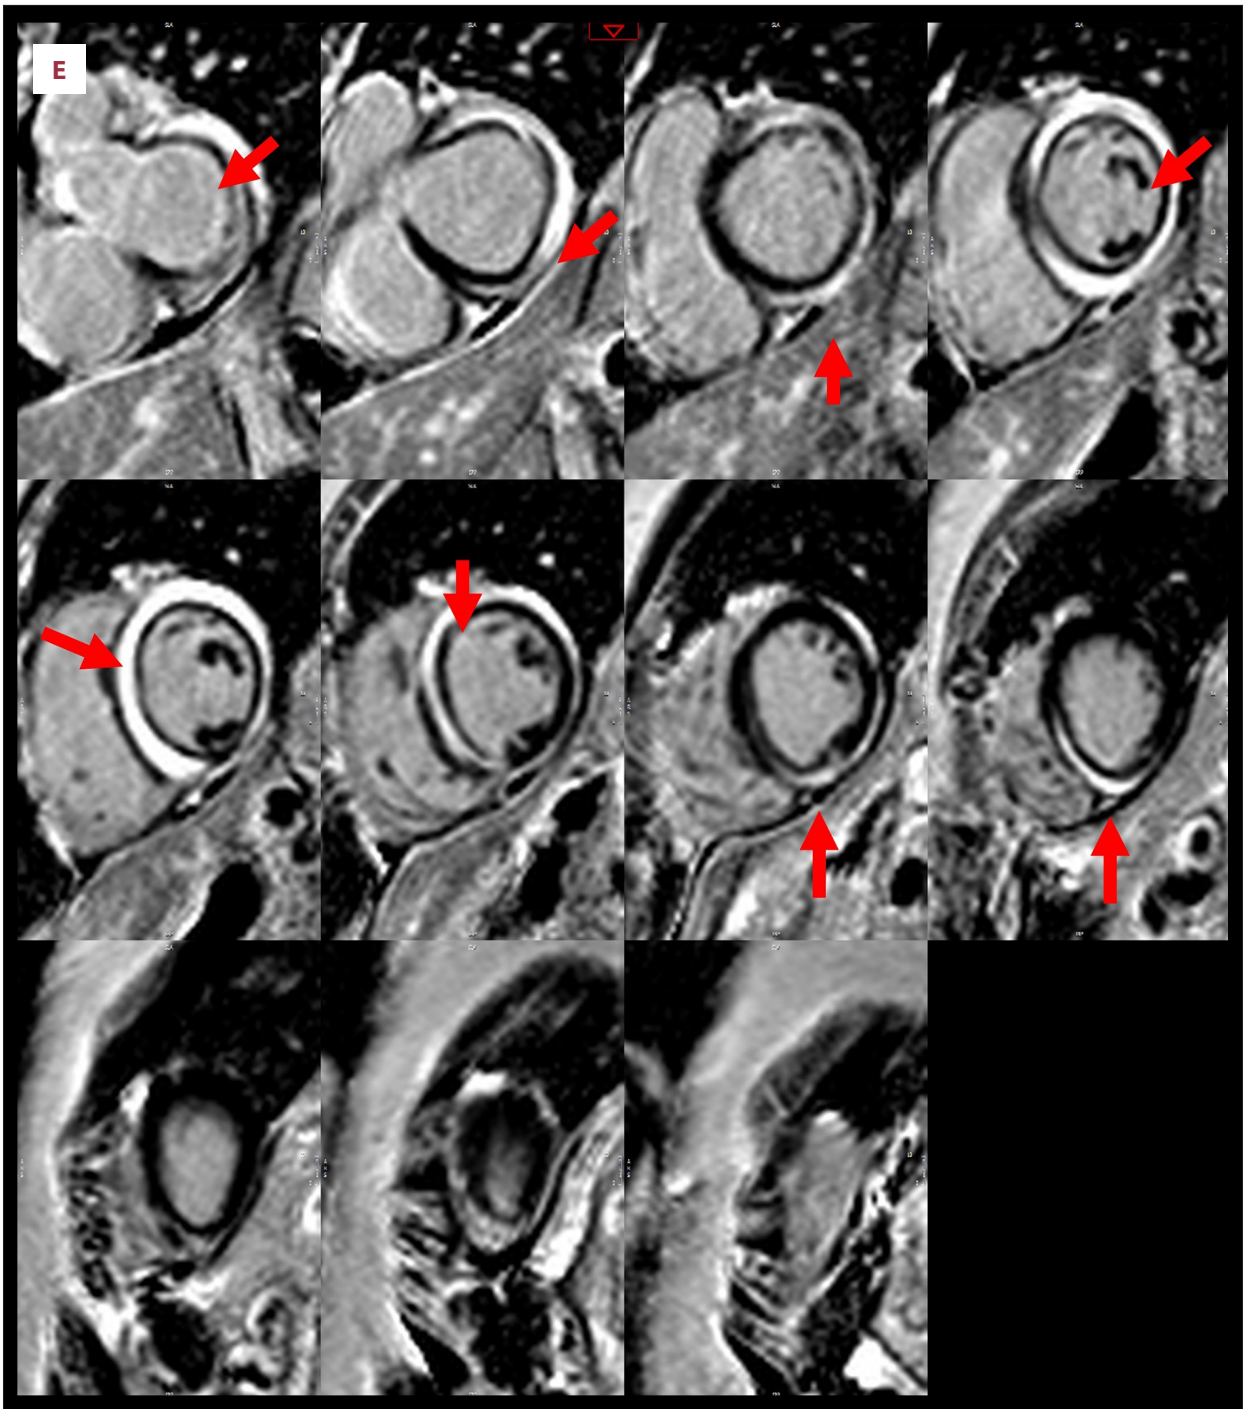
Cardiac MRI images demonstrating evidence of myocarditis. (A) STIR acquisition of mid-ventricular short axis: increased T2 signal intensity (SI) in the myocardium (SI myocardium: 275, SI skeletal muscle: 100). (B) MOLLI T1 map of mid-ventricular short axis: diffusely and focally (green arrows) increased T1 values (T1 mid-septal: mean 1170 msec, maximum 1364 msec). (C) T2-prepped SSFP T2 map of mid-ventricular short axis: diffusely- and focally-increased (blue arrows) T2 values (T2 mid-septal: mean 67 msec, max 80 msec). (D) PSIR late gadolinium enhancement (LGE) 4-chamber view. (E) Short axis stack: dense regions of mid-myocardial LGE (red arrows) consistent with acute injury, necrosis, and possible scarring.
